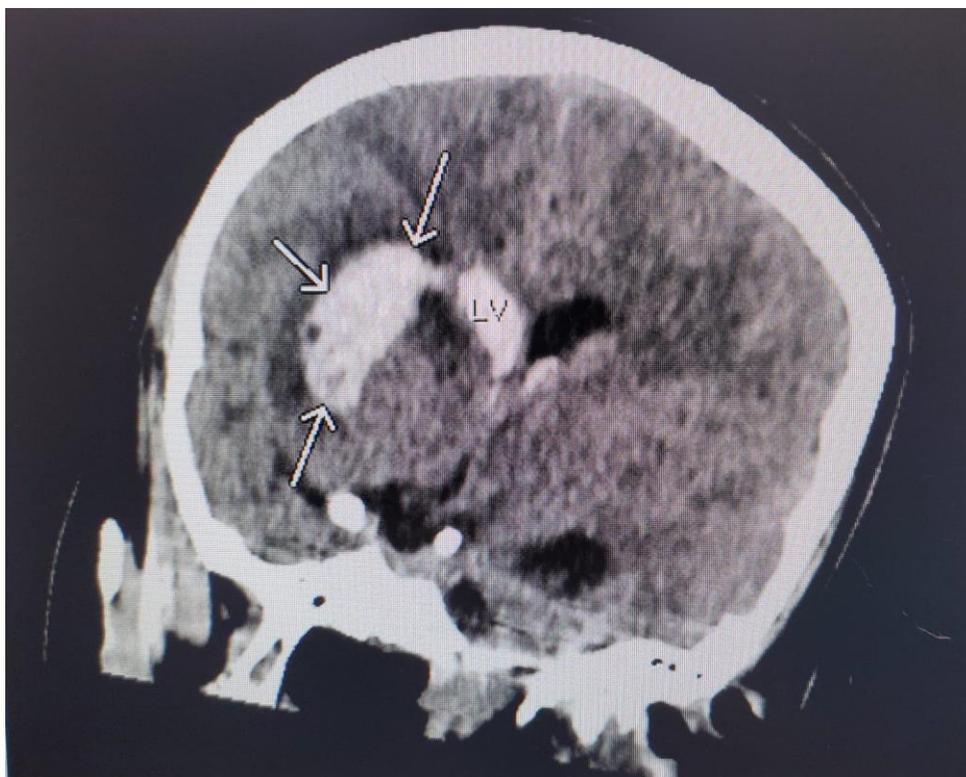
Image of the coronal view of a computed tomographic scan of the head.
